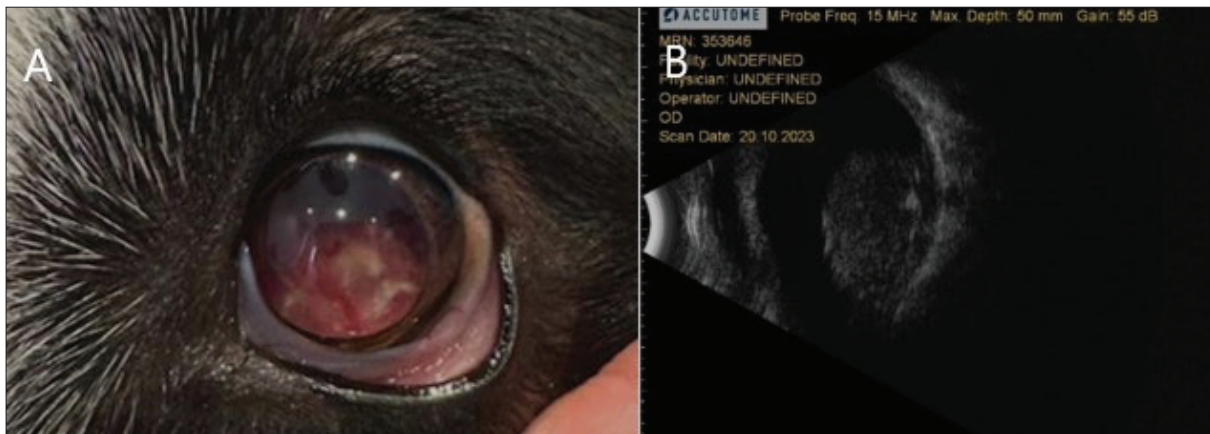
Ophthalmoscopic and ultrasonographic examination. A. Neoplastic mass enlarged into the posterior chamber and corpus vitreous, and leukocoria in the left eye internal angle, B. In the sonogram of the left eye, transversal sections showed an echogenic solid mass of retinal origin extending to the vitreous independent of papilla nervi opticus
